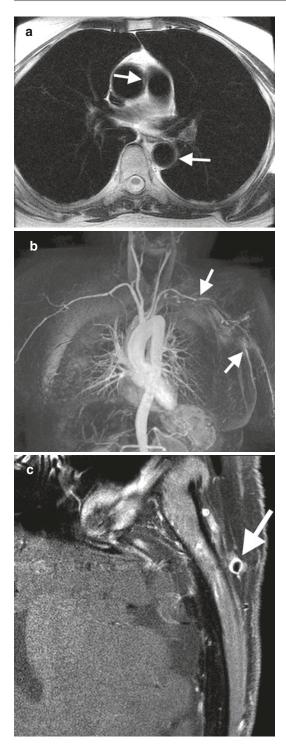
Giant cell arteritis in a 72-year-old female. (a) Axial MRI demonstrates left eccentric wall thickening ascending and descending aorta (*arrows*) and (b) MRA demonstrating long segment tapering stenosis (between *arrows*) of 50 % distal left subclavian extending into axillary artery. (c) High-resolution axial T1FS PG demonstrating wall thickening and enhancement of superficial temporal artery (*arrow*)
